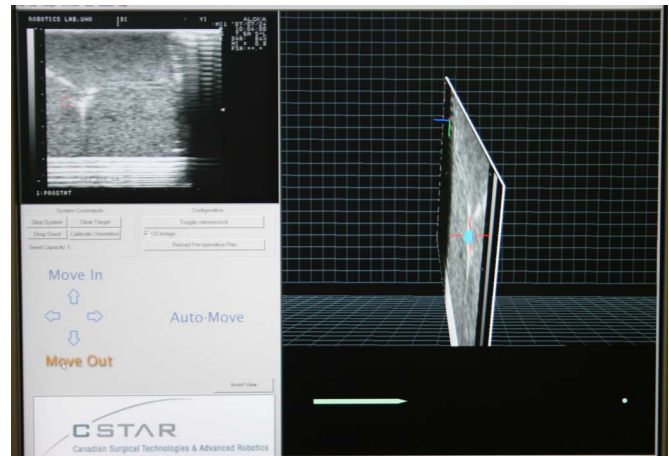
InterNAV3.0TM user interface showing the US image (Ultrasound View — top left corner), the position of the target (blue sphere) with respect to the needle tip (World View — top right), and the depth of the needle tip with respect to the target (Depth View — bottom right).
